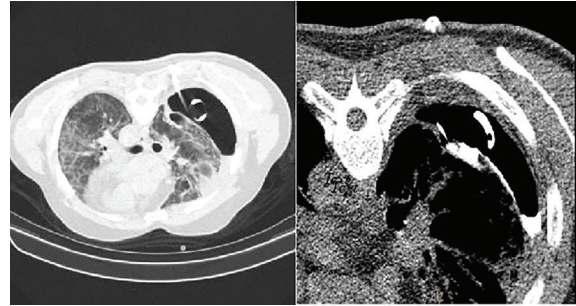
CT-guided percutaneous injection of cyanoacrylate glue and lipiodol into the BPF orifice in the first patient was performed. Since the solution had low viscosity, it leaked into the pleural space.
